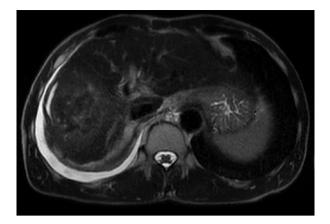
MRI liver (T2) demonstrating no enhancement of the lesion post-SBRT and immunotherapy. SBRT, stereotactic body radiation therapy.
